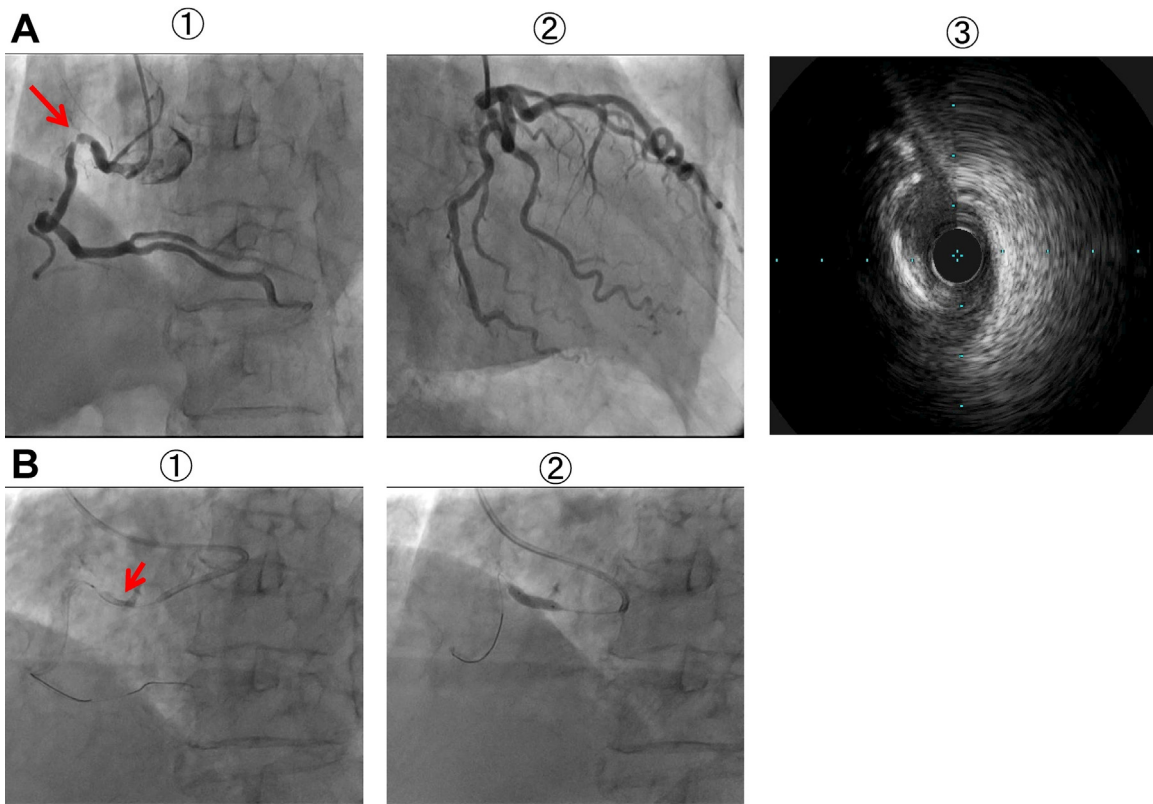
Coronary angiography Coronary angiography showed single-vessel disease with 90% stenosis in segment 1 of right coronary artery (A-①, arrow). The left anterior descending artery and left circumflex artery were patent (A-②). Intravascular ultrasound detected circumferential severe calcification (A-③). The stent was dislodged near the target lesion in the coronary artery. At first, we advanced a second guide wire external and distal to the dislodged stent, and subsequently twisted the two guide wires several times to allow their distal ends to intermingle. However, we could not trap the dislodged stent (B-①, arrow). Place of the dislodged stent in the proximal portion of RCA segment 1 after dilatation with a 4.0 × 15 mm balloon (NC Euphora, Medtronic Inc.) (B-②).
